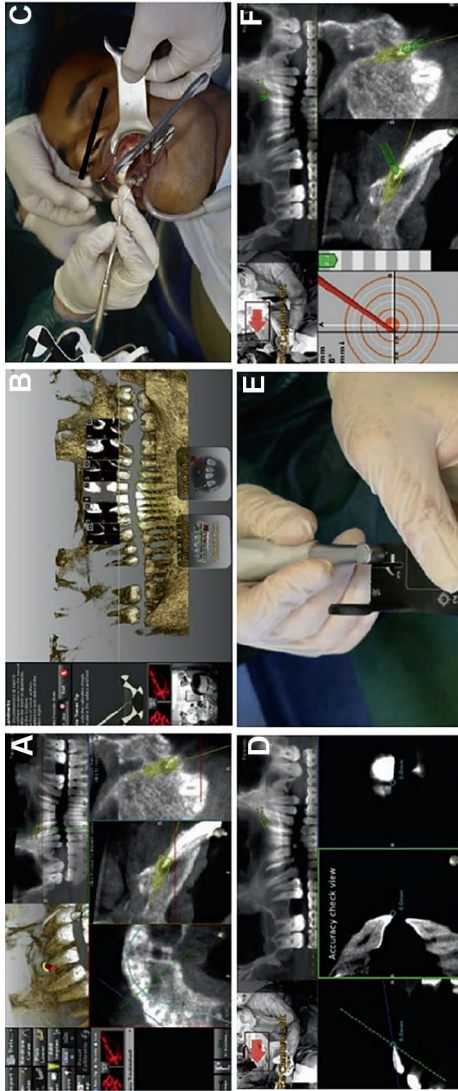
a Treatment planning using patient's CBCT scan. b Tracing, system calibration phase is performed by selecting 6 different points on software reconstructions. c Fixed support is mounted on patient's mouth that can be identified by the Navident cameras, after which the six preselected points are traced with a tool working as a support that can be recognized by the Navident for matching between the CBCT scan and the patient's jaw. d Tracing is completed by an accuracy check view. e Calibration of handpiece and burs before use. f Drilling under dynamic guidance. The direction and the angulation of bur during the surgery can be checked on 3 different CBCT views. (Courtesy: Gambarini et al., License no: 5130880615452)
